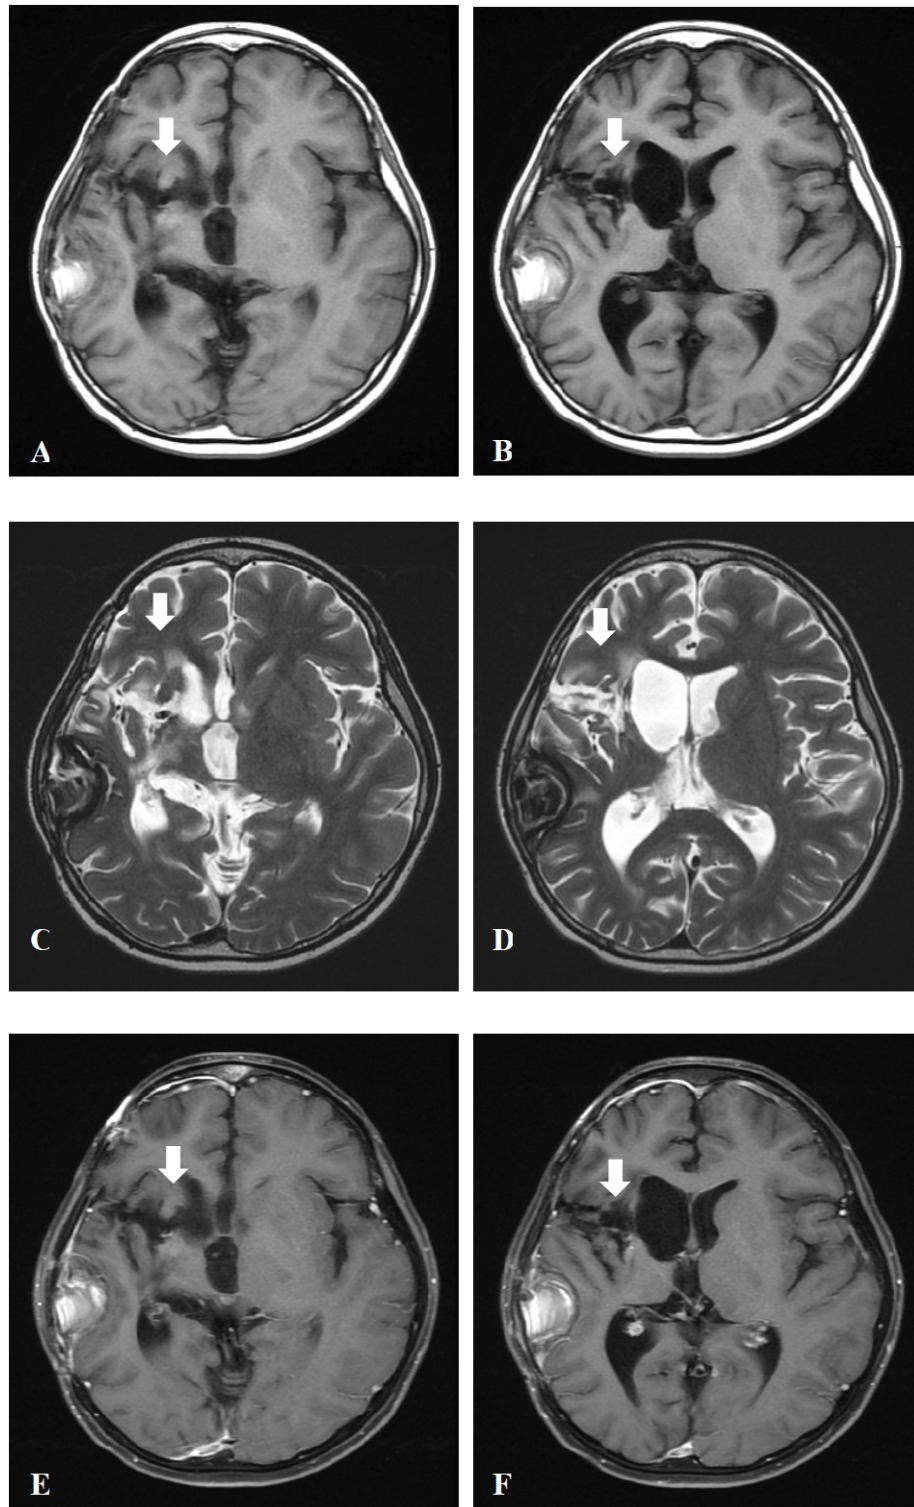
The followed brain MRI images on August 27, 2013, 4.5 years after operation. The MRI images of T1-weighted (A, B), T2-weighted (C, D) and T1 with contrast enhanced (E, F) showed the regional encephalomalacia over right basal ganglion area (white arrow), compatible with postoperative change. No evidence of tumor recurrence is mentioned.
